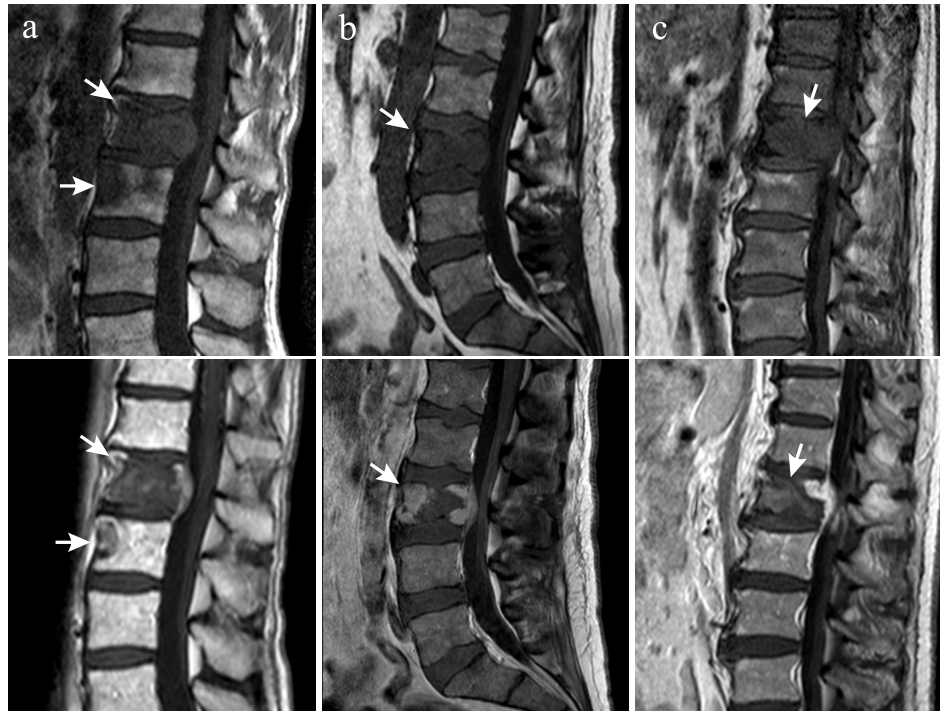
Pre- (upper row) and post-treatment (lower row) MRI scans of three exemplary patient cases (a-c) with corresponding metastases and necrosis zones (arrows). Shown are T₁-weighted (pre-RFA) and contrast-enhanced T₁-weighted (follow-up) scans.
